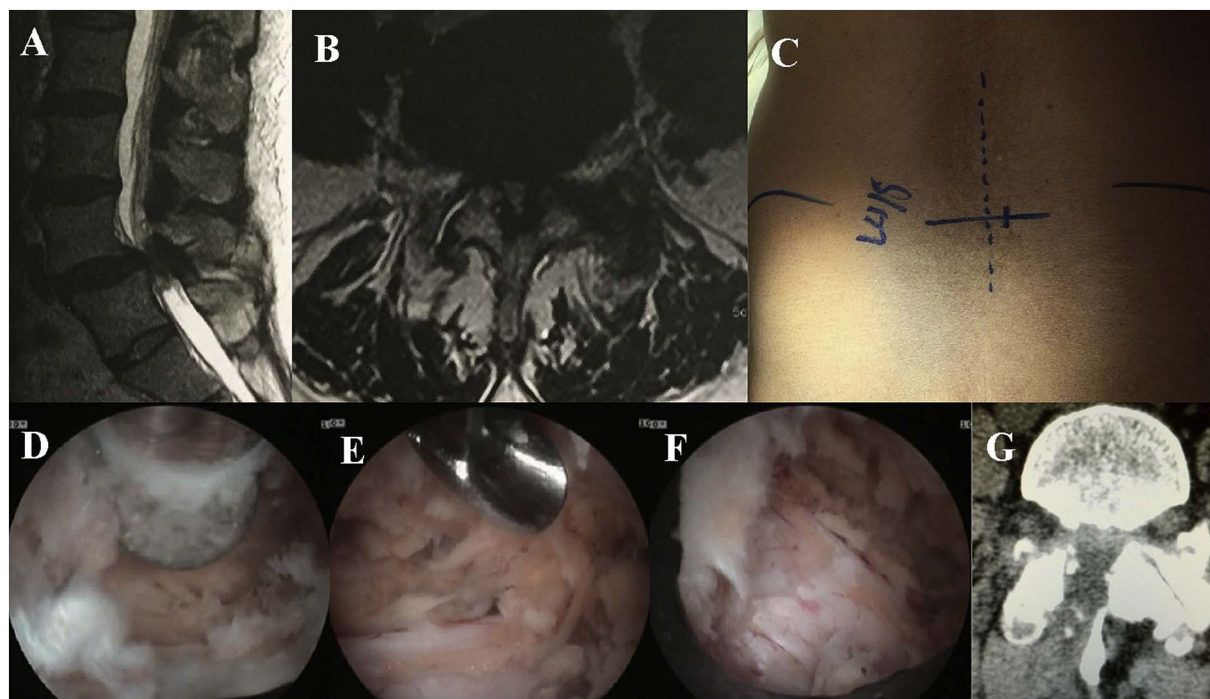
Lumbar 4–5 endoscopic laminectomy. A. T2 weighted sagittal MR image displaying the L4–5 stenosis. B. T2 weighted axial MR image displaying the L4–5 central stenosis and bilateral foraminal narrowing. C. Intraoperative photograph of the patient positioned prone with the midline marked (vertical dotted), the L4–5 disc space marked (horizontal solid), and the incision marked (1 cm solid vertical 1 cm line just off midline to the right). D. Endoscopic photograph of a high speed endoscopic drill with 4.5 cm head removing laminar bone. E. Endoscopic photograph of an endoscopic kerrison rongeur removing lateral recess bone. F. Endoscopic photograph of decompress thecal sac. G. Postoperative axial CT image at the level of the L4–5 disc space demonstrating the decompression.
